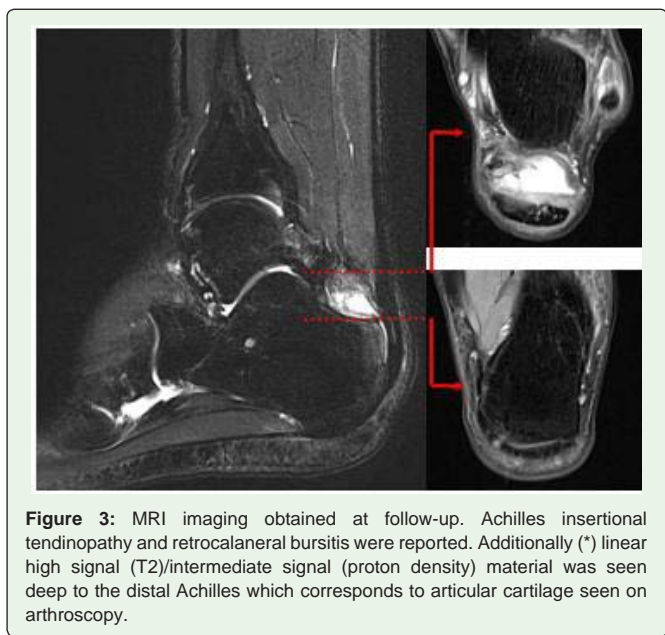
MRI imaging obtained at follow-up. Achilles insertional tendinopathy and retrocalaneral bursitis were reported. Additionally (*) linear high signal (T2)/intermediate signal (proton density) material was seen deep to the distal Achilles which corresponds to articular cartilage seen on arthroscopy.
